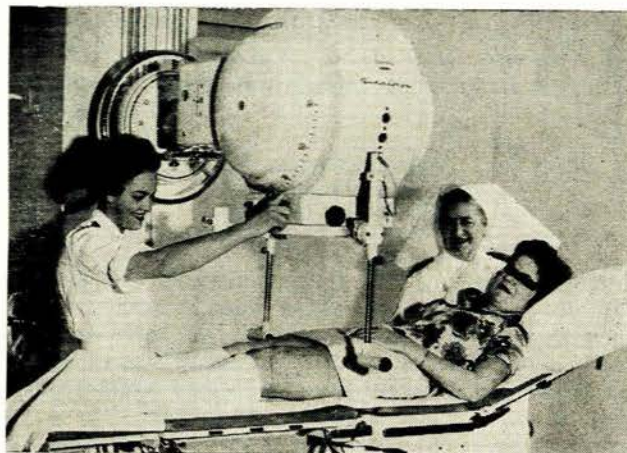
2,000 Curie Telecobalt 'bomb'. The patient being treated by Mrs. Raats, senior radiographer-in-charge, and sister Taylor.
